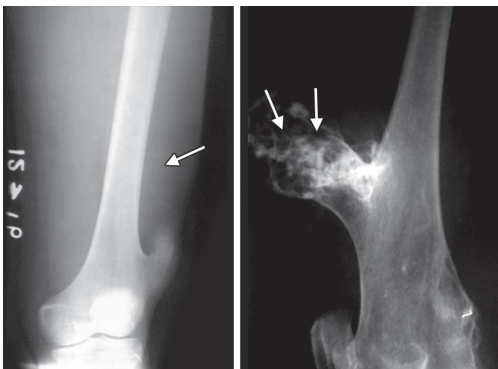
X-ray: Osteochondroma (distal femur)
